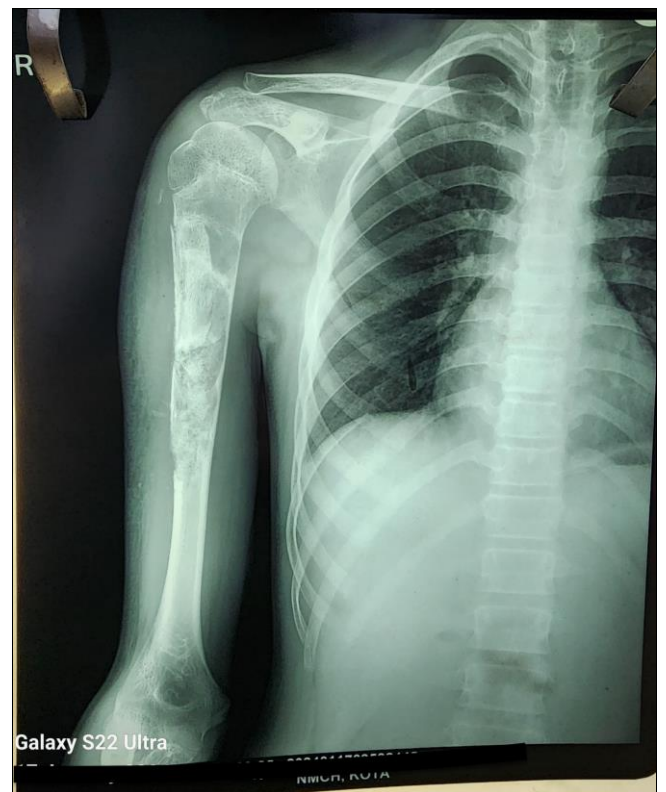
Postoperative 6-week X-ray of the Right Shoulder AP View
